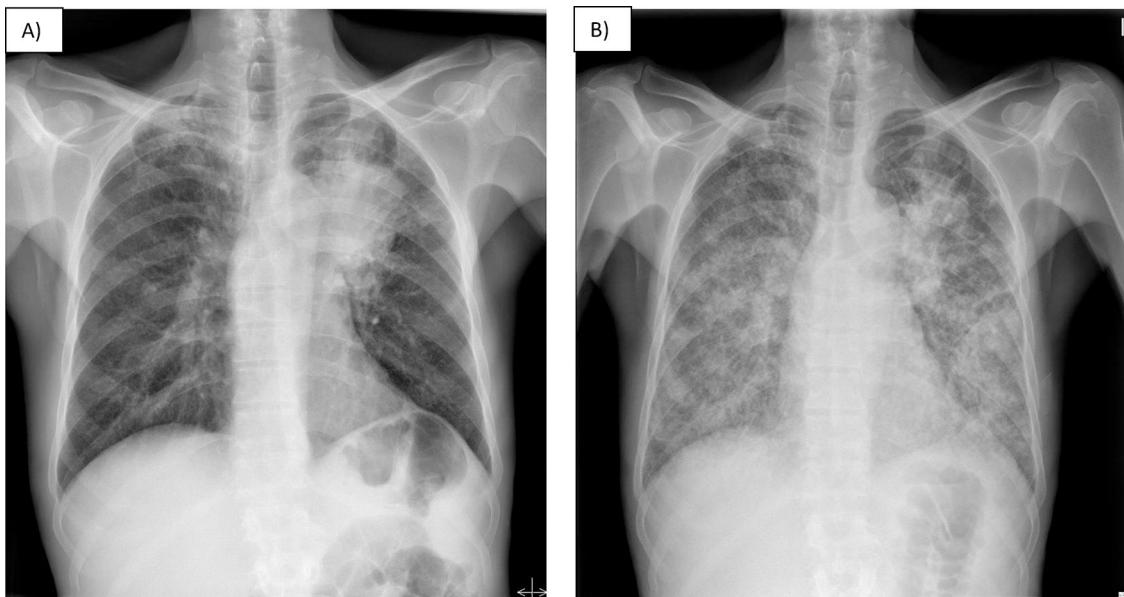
Radiological progress throughout hospital admission. Chest X-ray on admission (A) revealing a lung mass measuring 10 cm×5 cm causing atelectasis of the left upper lobe, along with apical fibrosis and calcified granulomas. Chest X-ray 14 days after admission (B) revealing bilateral diffuse micronodular interstitial infiltrate not present on the previous X-ray.
